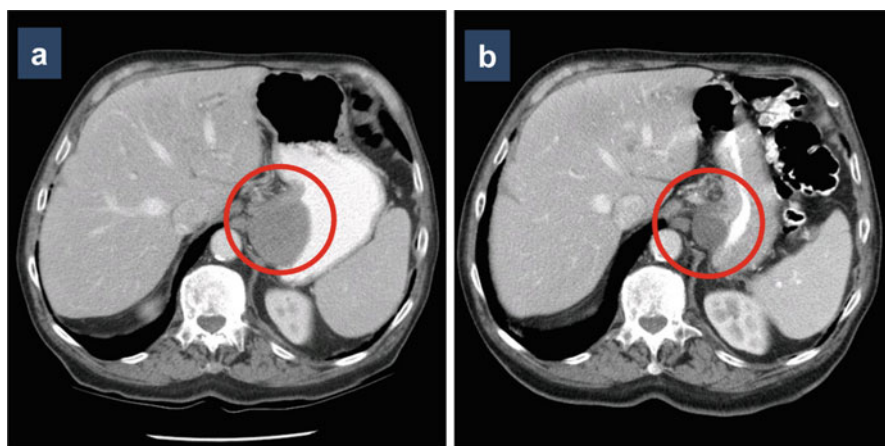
CT scans in a patient with gastroesophageal junction GIST (*red circle*) before (a) and after (b) 3 months of neoadjuvant imatinib, showing partial response
